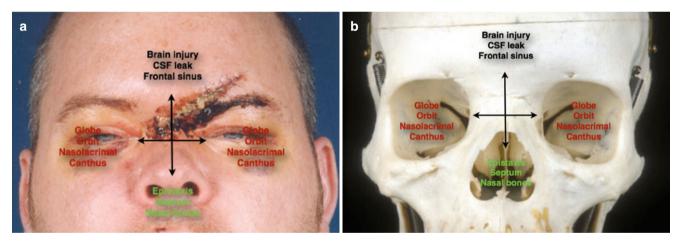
Nasoethmoid fractures can be deceptive and present with an array of clinical signs and symptoms, depending on their severity (a, b). They are not always symmetrical and unilateral injuries may occur. These require careful evaluation, notably with CT imaging
